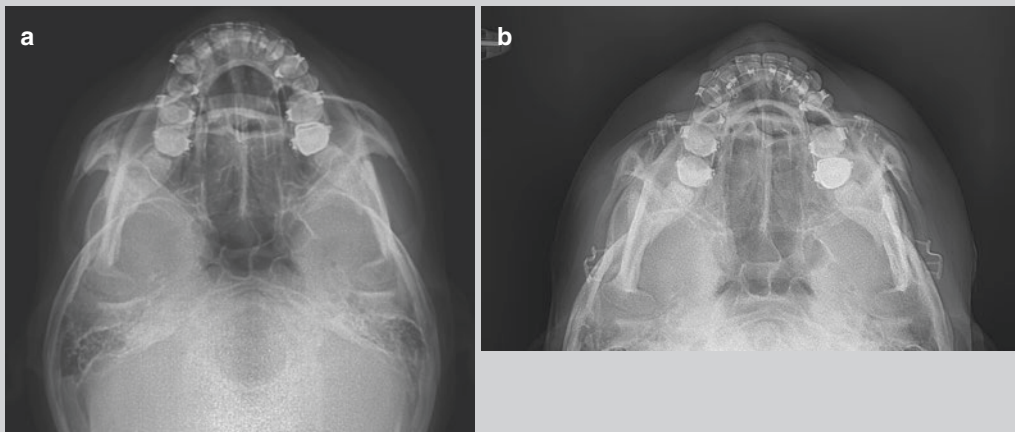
Case 1.* (a) Preoperative and (b) postoperative radiographic showing posteromedial repositioning of the zygoma
